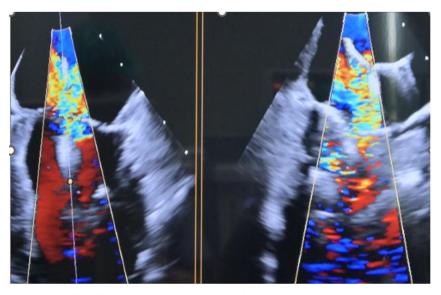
Simultaneous biplane (left: four-chamber view and right: five-chamber view), two-dimensional transesophageal views, and color flow of the TEER delivery system inserted through the cardiac apex position at the mitral valve level. Notice that the mitral valve leaflets were on the upper surface of the lower clip, which was inside the left ventricle, whereas the upper clip was inside the left atrium.
